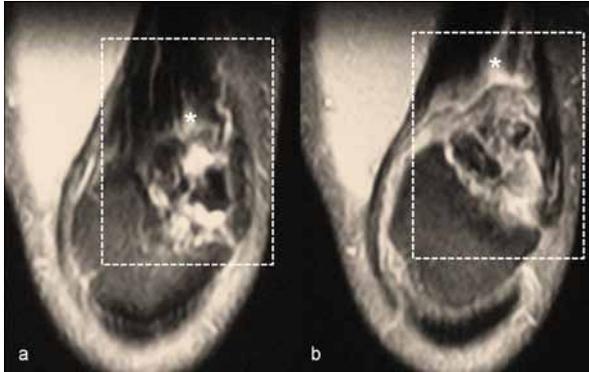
The coronal (a), (b) fat suppressed PD-w MR images verify fragmentation of the superolateral-lateral patellar pole (dashed line) and chronic tendinopathy of the vastus lateralis insertional tendon fibers (asterisks).
